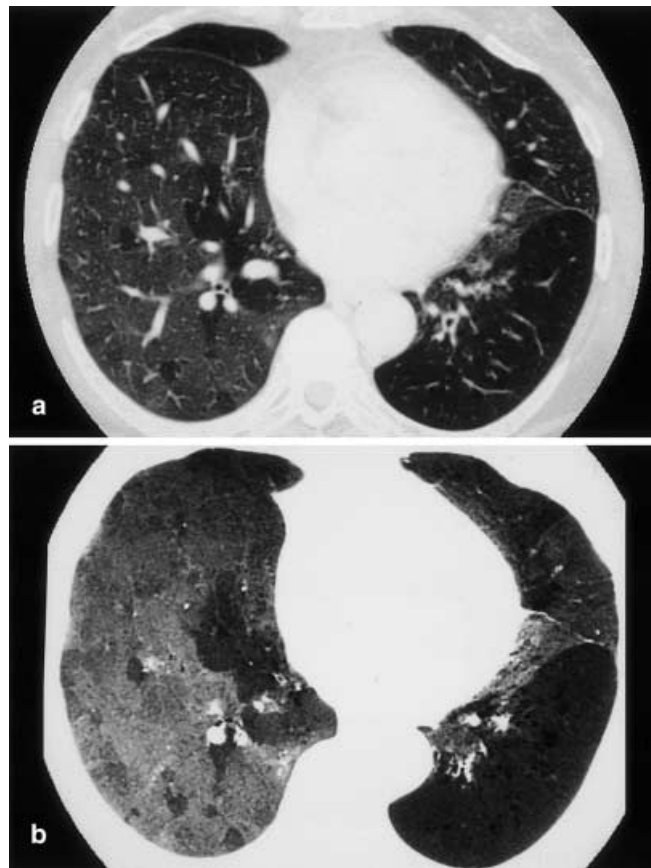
Continuous expiratory CT in a case of postinfectious constrictive bronchiolitis. a Thin-section expiratory scan acquired with helical CT acquisition during continuous expiratory maneuver, showing air trapping in the postero- and laterobasal segments of the left lower lobe. Multiple lobular areas of air trapping are also visible in the right lower lobe and lingula. b Minimal intensity projection in axial direction obtained from the data set (10-mm-thick volume scanned with helical acquisition and 1.5-mm collimation) increasing the contrast in attenuation between the areas of air trapping and normal parenchyma
